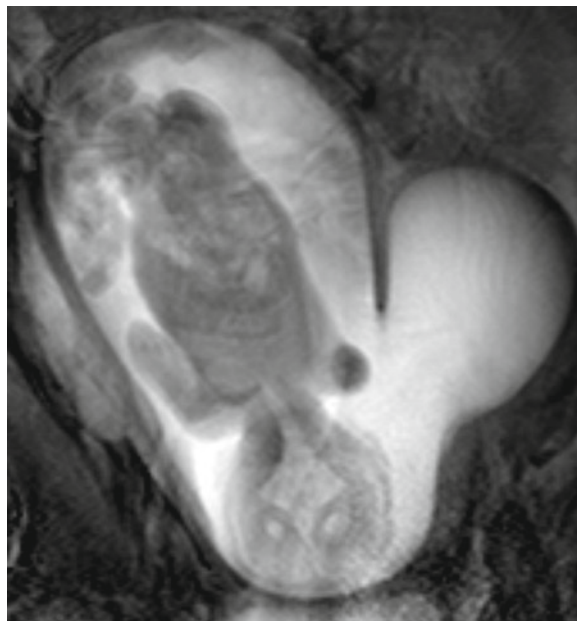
On a frontal MRI scan (FLAIR sequence) of the gravid uterus in GW 23 a septum based on the uterine fundus is seen. The placenta is located in the right uterine horn and on the septum
